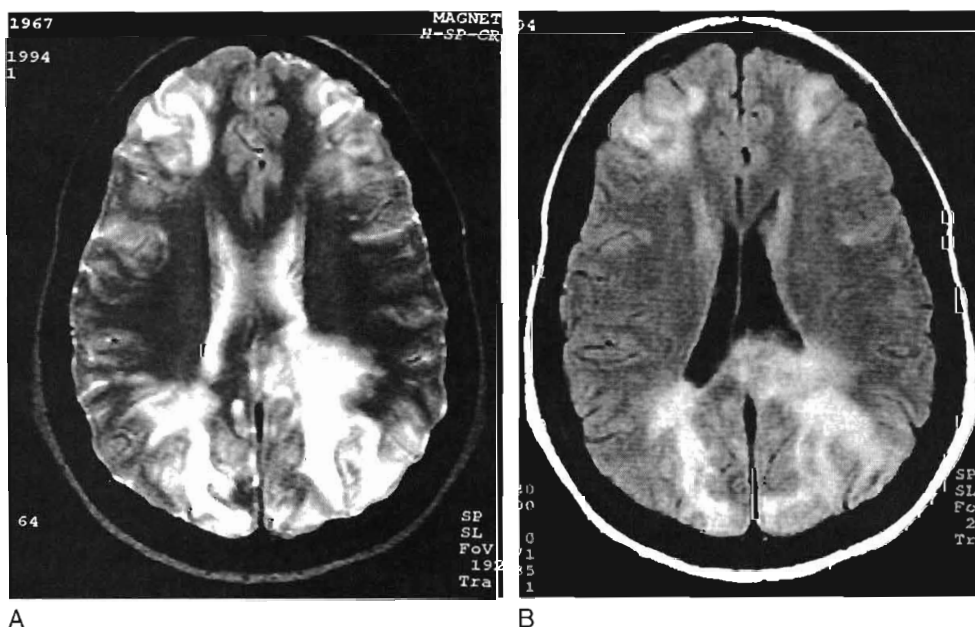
Progressive multifocal leukoencephalopathy. Axial T2-weighted (A) and fluid-attenuated inversion recovery (FLAIR) (B) images in a patient with human immunodeficiency virus (HIV). Multiple areas of white matter disease are identified; the FLAIR image increases their conspicuity. These findings in an HIV-positive patient indicate a postinfectious demyelinating process—progressive multifocal leukoencephalopathy.
